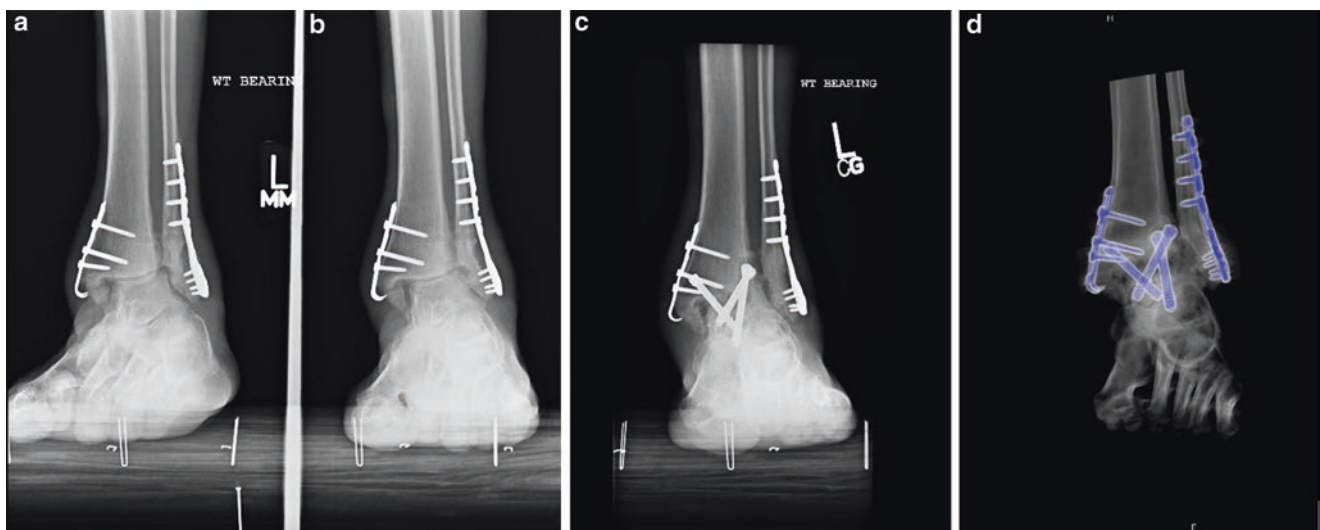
(a, b) Diabetic patient with malunion ankle fracture. (c, d) Arthroscopic ankle arthrodesis was attempted and resulted in continued malunion. (e) CT scan with hardware addition demonstrating nonunion, subtraction may also be utilized
